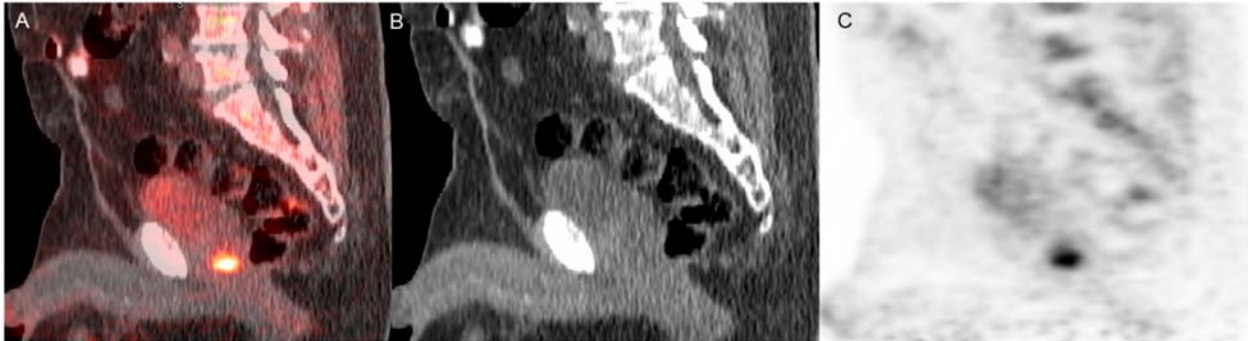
66 year old male with biochemical recurrence of prostate cancer (PSA of 29.3 ng/mL). ¹⁸F-fluciclovine PET-CT found a single suspicious focus of uptake in the prostate resection bed. Sagittal (A) fused PET-CT, (B) CT, (C) PET. Patient underwent external beam radiation of lesion with corresponding PSA nadir (0.27 ng/mL)
